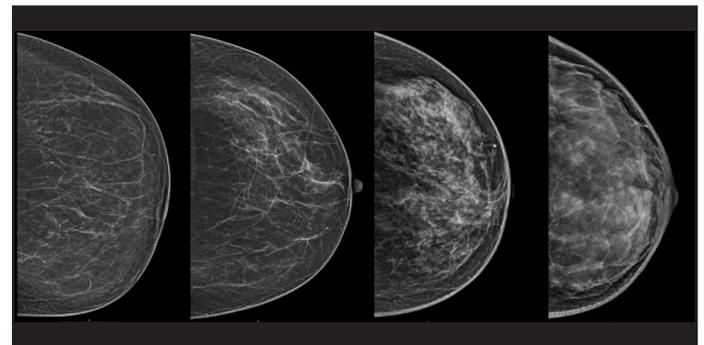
A-D mammographic density on CC radiographs of the left breast (left to right respectively).
